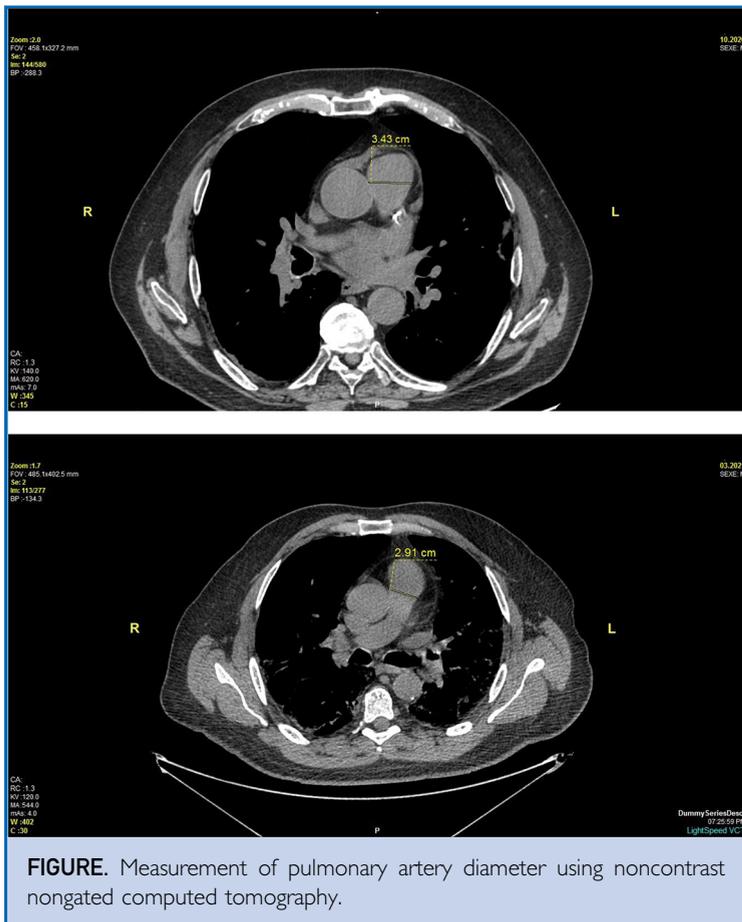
Measurement of pulmonary artery diameter using noncontrast nongated computed tomography.
